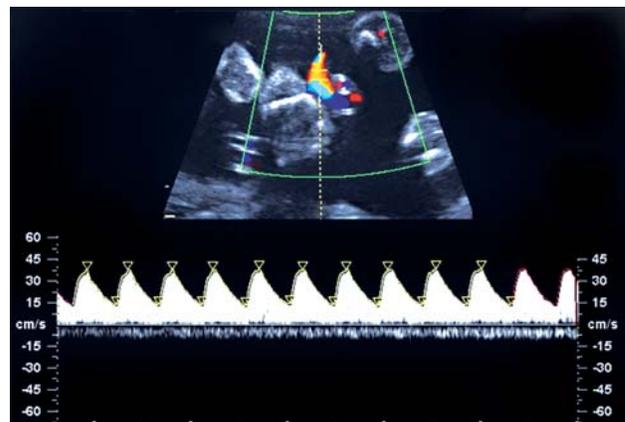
Spectral Doppler. Umbilical artery. Free loop
